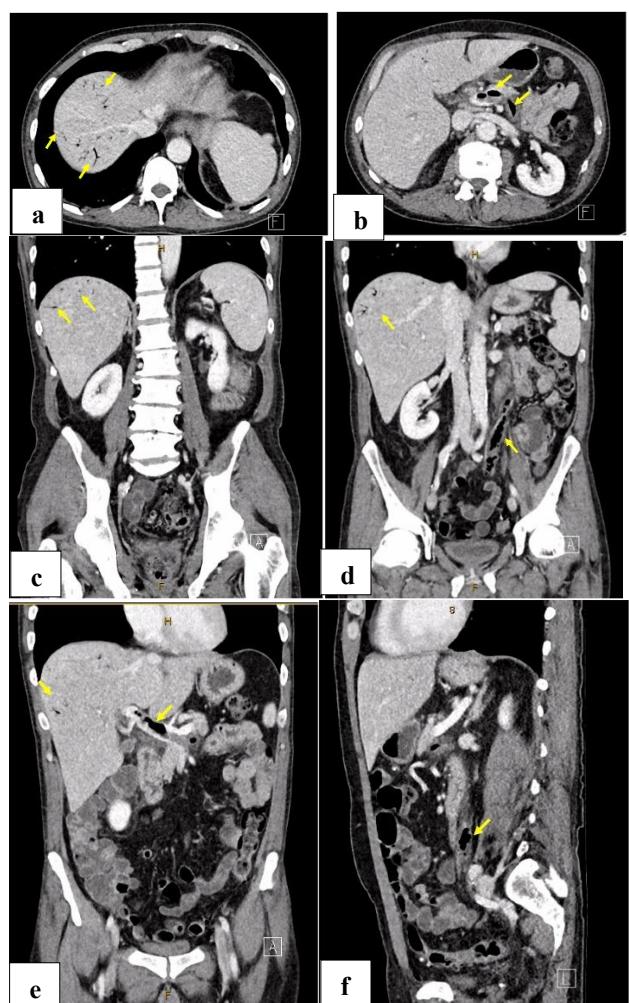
(a) CT axial, peripheral branching lucencies consistent with portal gas; (b) CT axial, gas tracking to portal vein; (c) CT coronal, peripheral branching lucencies consistent with portal gas; (d) CT coronal, peripheral branching lucencies consistent with portal gas, and tracking to IMV; (e) CT coronal, peripheral branching lucencies consistent with portal gas, and tracking to portal vein; and (f) CT sagittal, gas tracking to portal vein.
